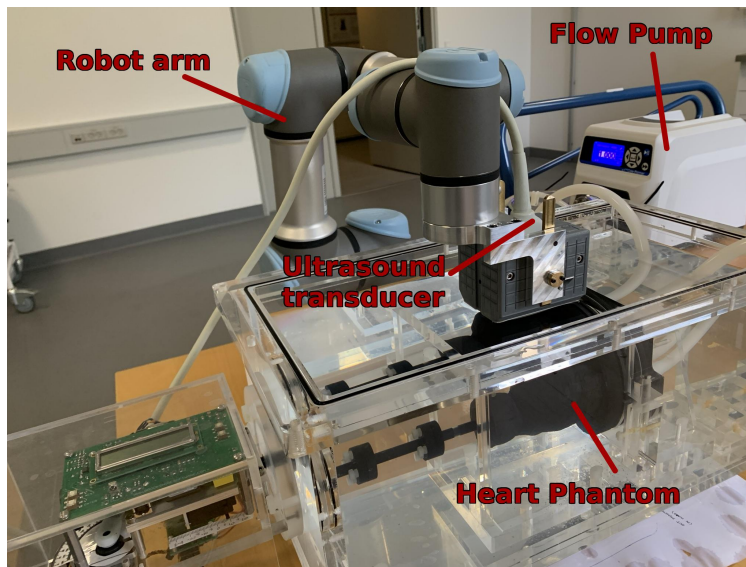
Picture of controlled ultrasound scanning of the DHP. The ultrasound transducer is mounted in a custom mount which ensures repeatability between measurements. The cavities in Fig. 4.5 are based on controlled ultrasound scans utilizing the robot arm as seen in this picture.
